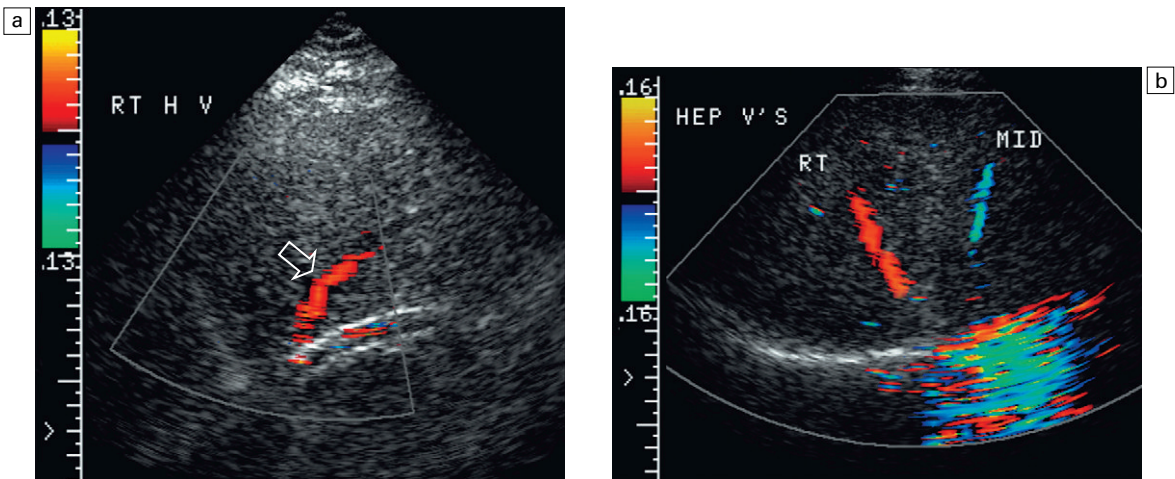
(a) Longitudinal colour Doppler image including the right hepatic vein and TIPS shunt. Note the poor colour saturation of the TIPS indicating poor flow. Colour signal from the right hepatic vein shows flow coursing through the transducer, which is away from the inferior vena cava. This is a result of focal stenosis at the hepatic vein junction with the TIPS shunt. (b) Transverse image of the same patient as in Figure (a). Flow in the right hepatic vein is indeed coursing away from the heart. It collateralises to the mid-hepatic vein which shows the appropriate flow direction back towards the IVC.
